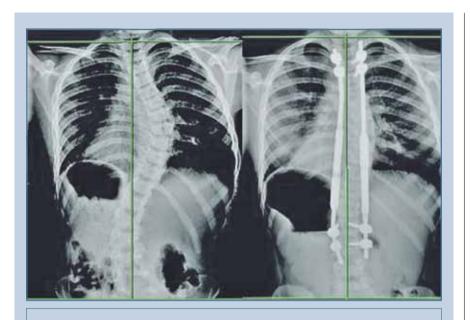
Pre- and postoperative radiographs of the spine in an 8-year-old patient with idiopathic scoliosis, the follow-up period is 23 months [38]
